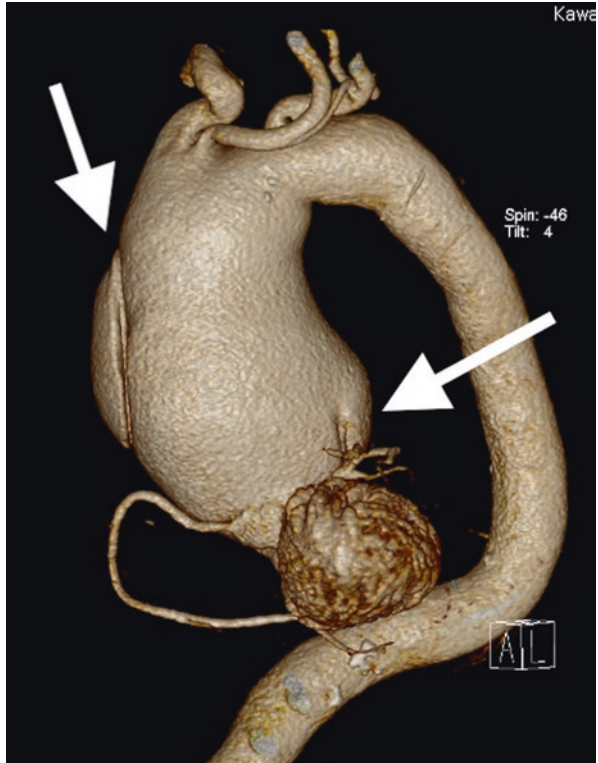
CT angiography of the same patient presenting an aortic aneurysm with a type I DeBakey Stanford A dissection with two tears (arrows)
